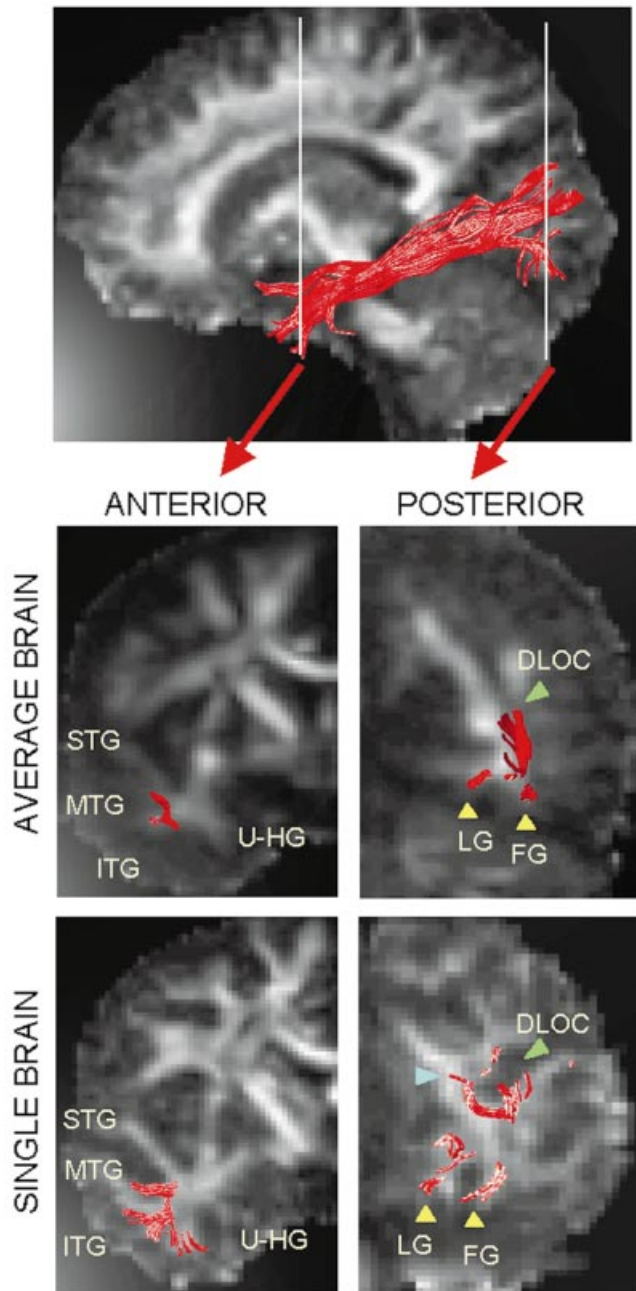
Terminal branches of the ILF in the temporal (left column) and occipital (right column) ROIs in the average and single brains. The fibres are co-registered on coronal slices of the average DT-MRI brain (the slice locations are indicated in the sagittal section at the top of the figure). The top pair of images relates to the average brain, the bottom pair to the single subject brain. In the occipital lobe, the ILF originates from the dorso-lateral occipital cortex (green arrowhead), cuneus (blue arrowhead), posterior lingual and fusiform gyri (yellow arrowhead). The terminal branches are not as well defined in the average as in the single brain, although it is possible to recognize a similar distribution of the fibres. STG = superior temporal gyrus; MTG = middle temporal gyrus; ITG = inferior temporal gyrus; U-HG = uncus/parahippocampal gyrus; LG = lingual gyrus; FG = fusiform gyrus; DLOC = dorso-lateral occipital cortex.
